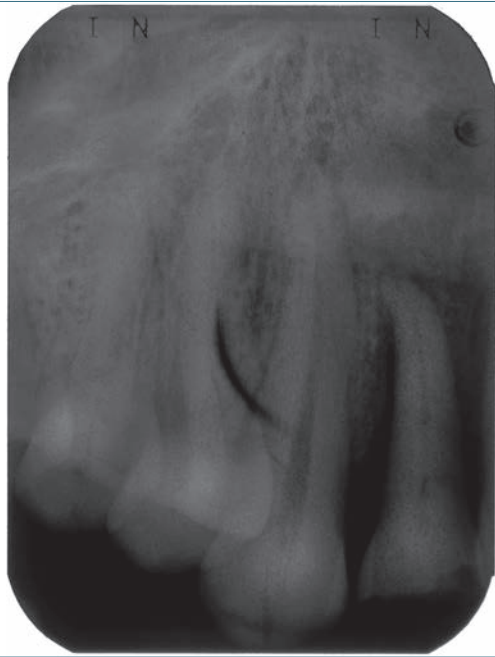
X-ray showing "crimping" or fingernail marks.
